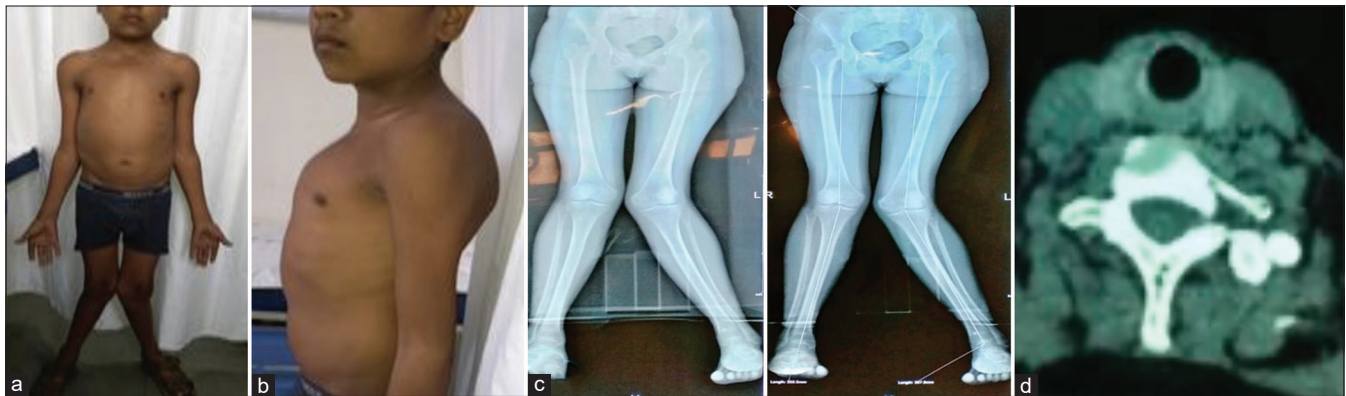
(a and b) show clinical photographs of the patient with genu valgum and pectus carinatum deformity, (c) shows a scannogram with bilateral genu valgum deformity, and (d) shows an axial CT image with a mass located posteroinferior to the right lobe of the thyroid gland
